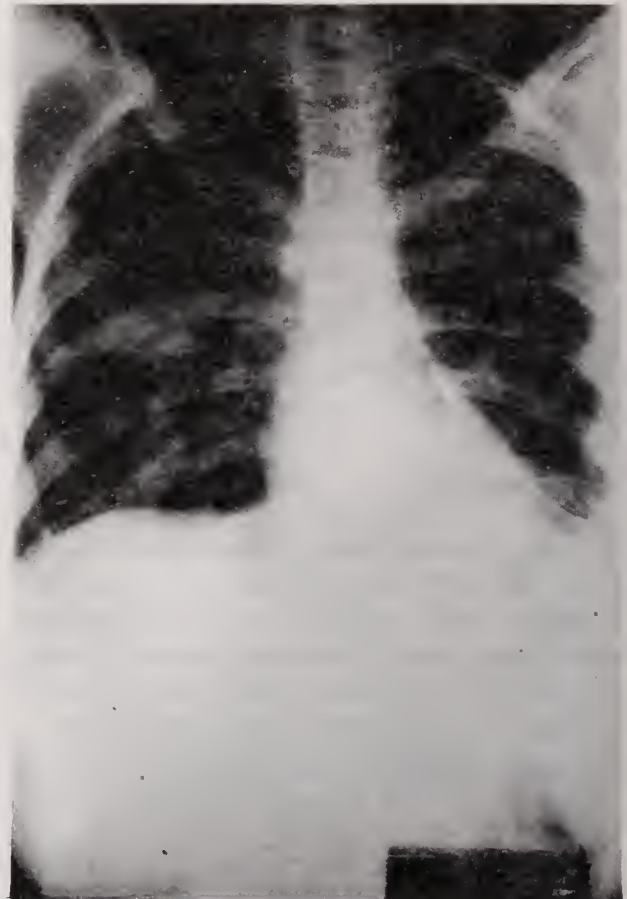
Chest radiographs 24 h apart. (A) dated December 17 showing an extensive pneumonic infiltrate in the anterior segment of the right upper lobe and in the right lower lung field. A nodular density near the left hilum has reappeared; (B) dated December 18 showing rapid resolution of the radiodensities.
